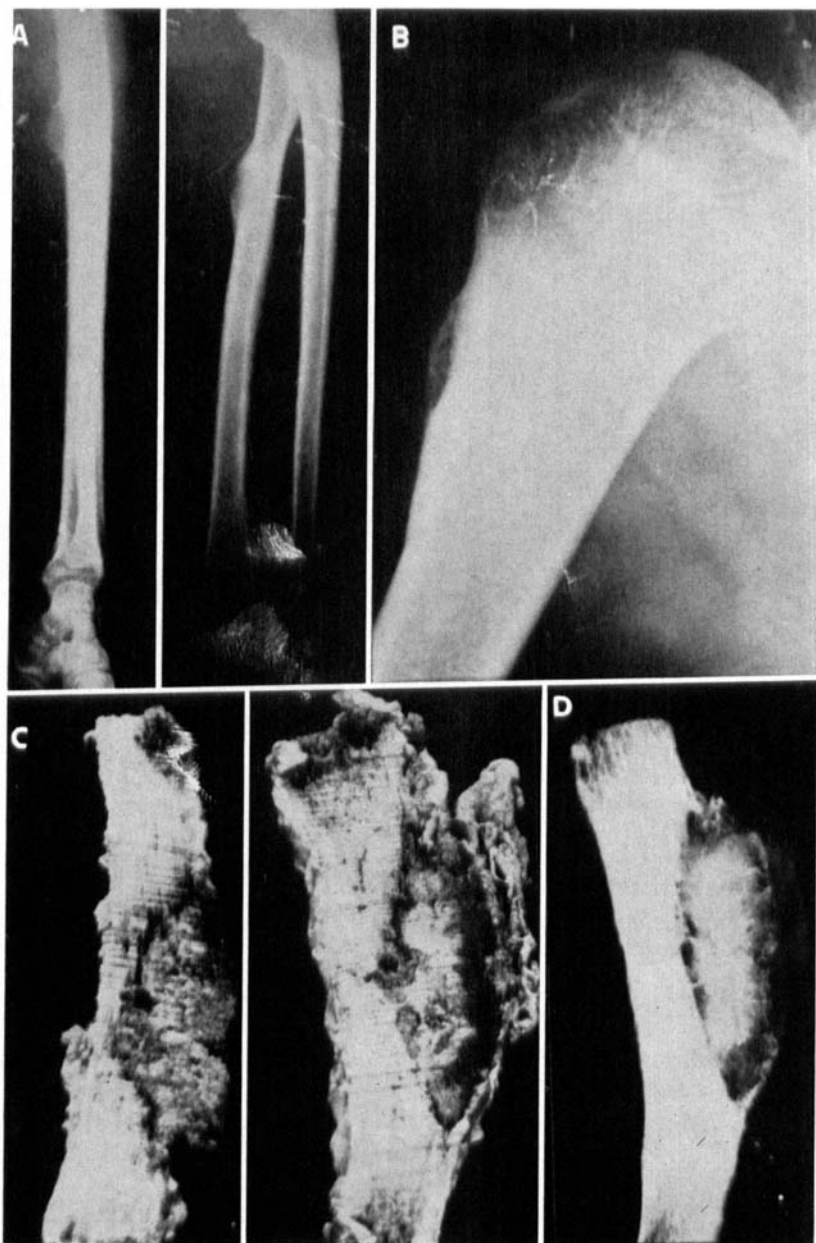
Different aspects of periosteal osteoblastomas. A. Case No. 16257, 30-year-old male. Lateral and antero-posterior roentgenogram of non-sclerosing peripheral lesion of the upper third of radius. B. Case No. 15916, 19-year-old male. Similar lesion but of the upper third of the humerus with a thin shell of newly formed
